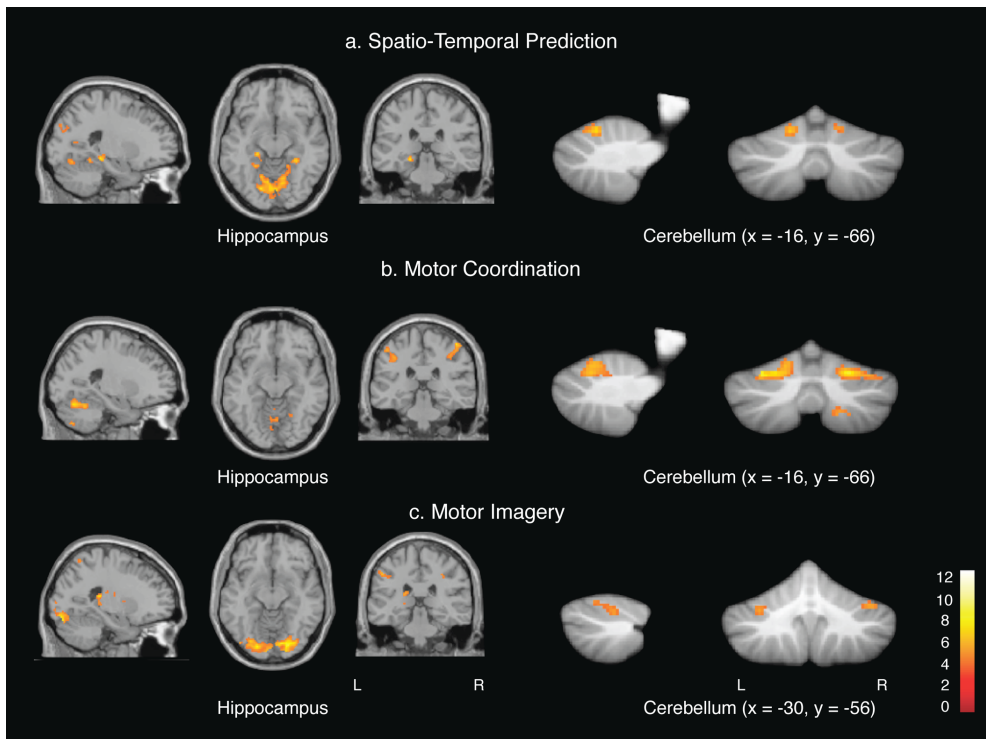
Functional MRI of hippocampal and cerebellar activity during spatio-temporal prediction, motor coordination, and motor imagery. Spatio-temporal prediction (a) was assessed by the contrast Corresponding Finger condition—flash marker condition, motor coordination (b) was assessed by the contrast Corresponding Finger condition—Four-Finger condition, and motor imagery (c) was assessed by the contrast mental rehearsal condition—observation condition. To allow comparison of hippocampal activation across the different contrasts, the x, y, and z planes are kept constant. The x and y coordination of cerebellar activations are displayed on the Figure. Note that the hippocampus was only activated during spatio-temporal prediction.
